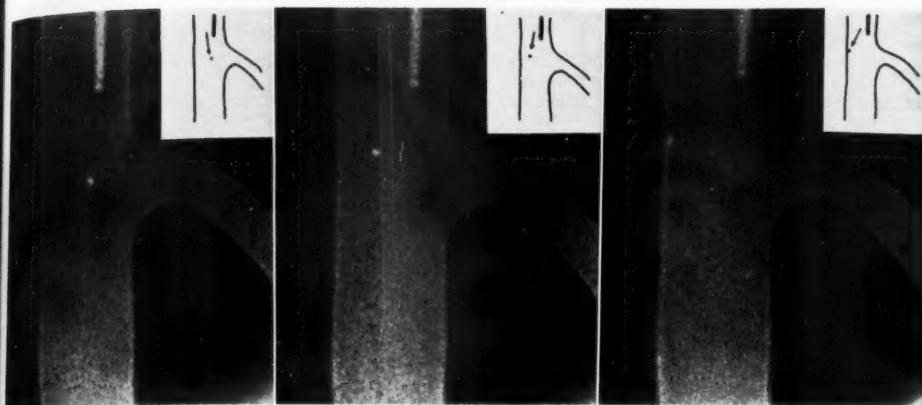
A water current pouring from a narrow glass tube into a wider one pushes the streamer from the middle to the extreme left. X-ray cinefilm study through an image amplifier.
